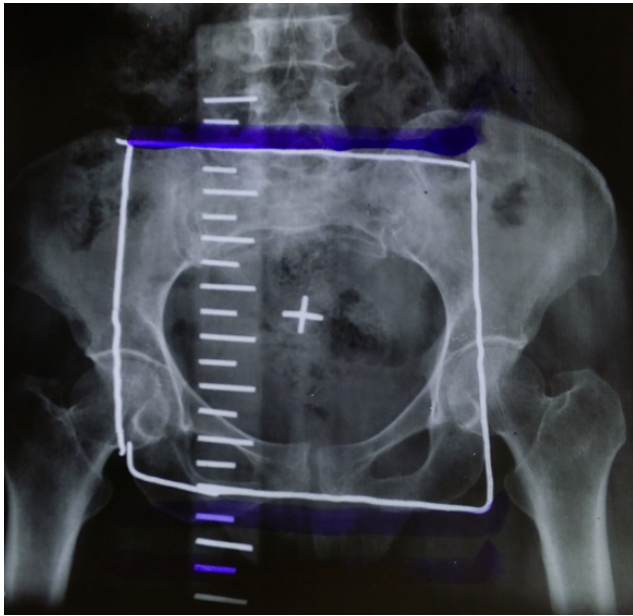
X-ray of pelvis with the area marked for external beam radiotherapy
